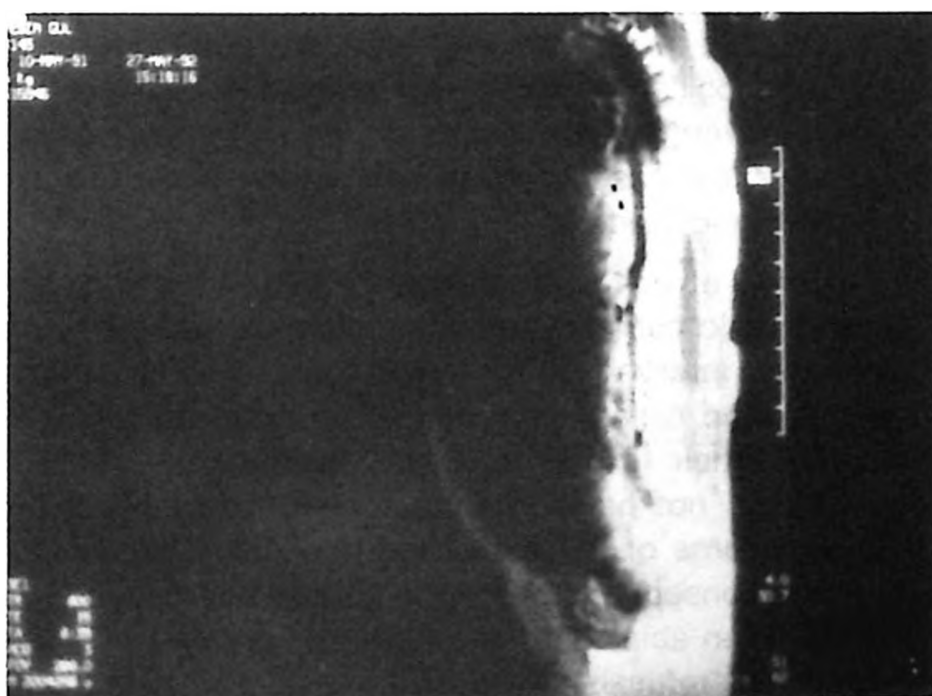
Sagittal T₁ weighted MR imaging revealed a thin, elongated spinal cord terminating with a lipoma and cervical-thoracic syringomyelia. (SE, TR 500, TE 15)
